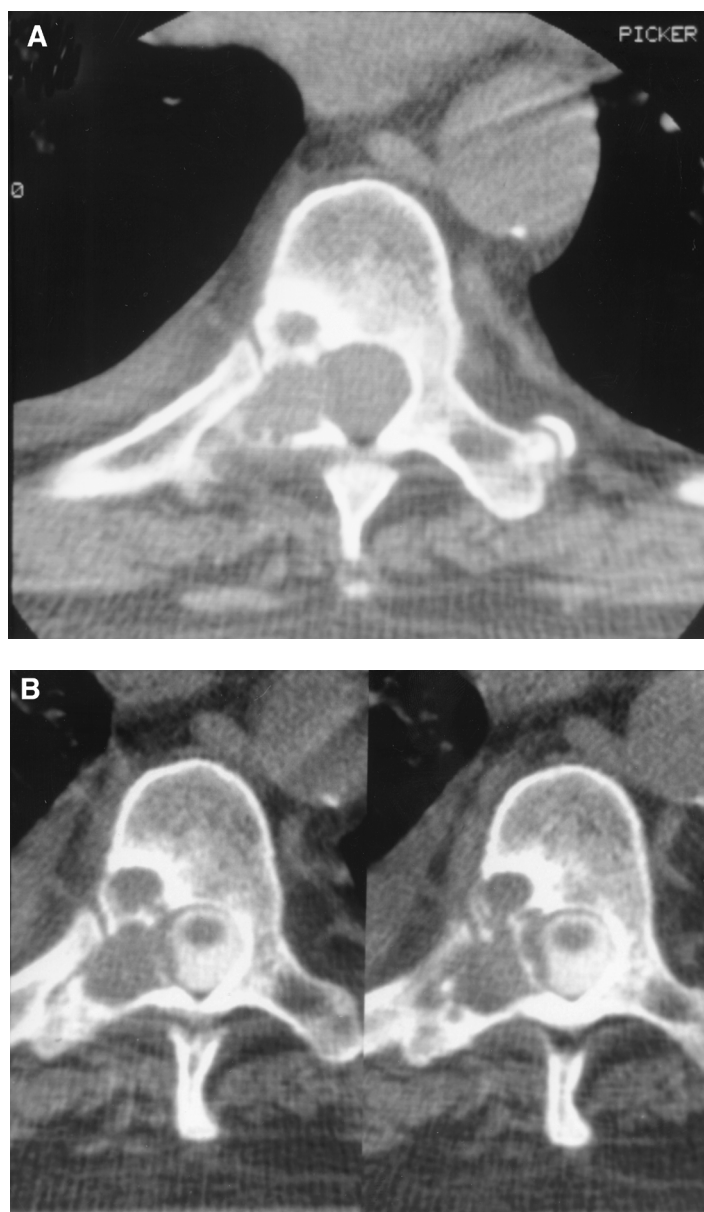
(A) Plain CT scan showing pedicle destruction. (B) CT scan following myelography showing compression of dural sac.
